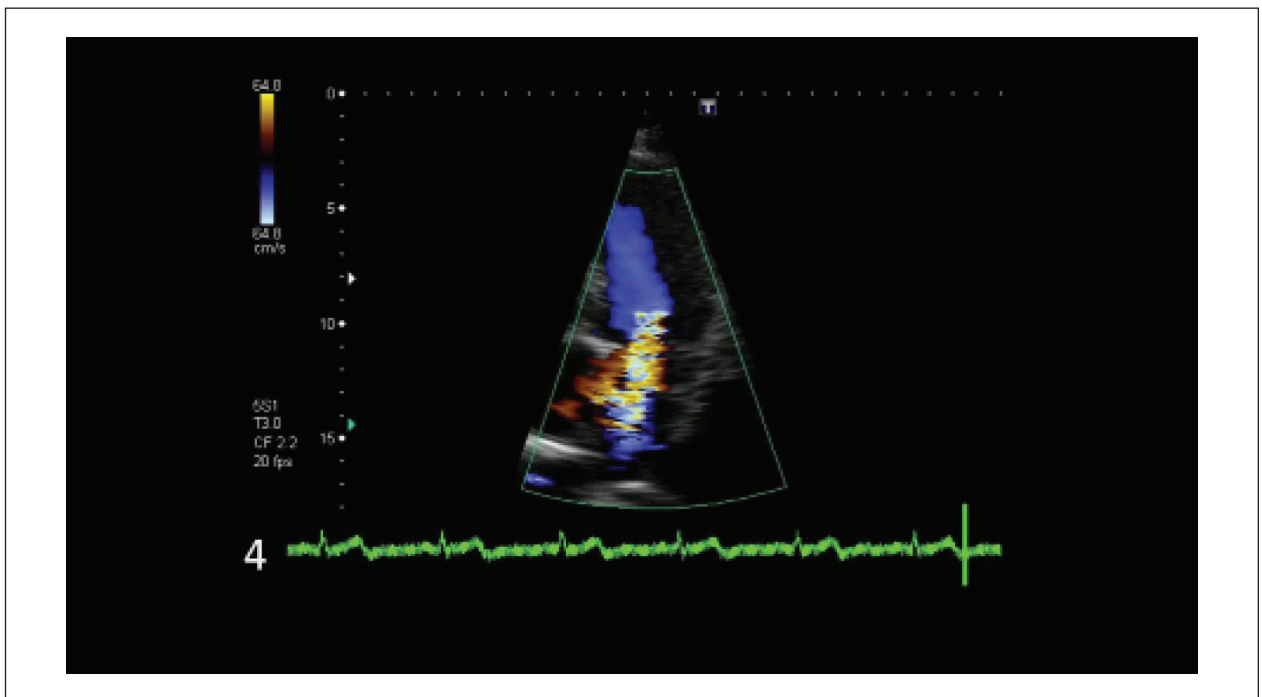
Echocardiogram after 7 years of the start of dopaminergic medication. A - 4-chamber apical view showing slight to moderate aortic regurgitation (yellow arrow); B - Parasternal short axis view at the level of the mitral valve showing valve thickening; C - Apical view showing moderate to severe mitral regurgitation (yellow arrow); D - Transmittal continuous Doppler showing medium diastolic gradient LA-LV 9 mmHg, compatible with moderate stenosis.
